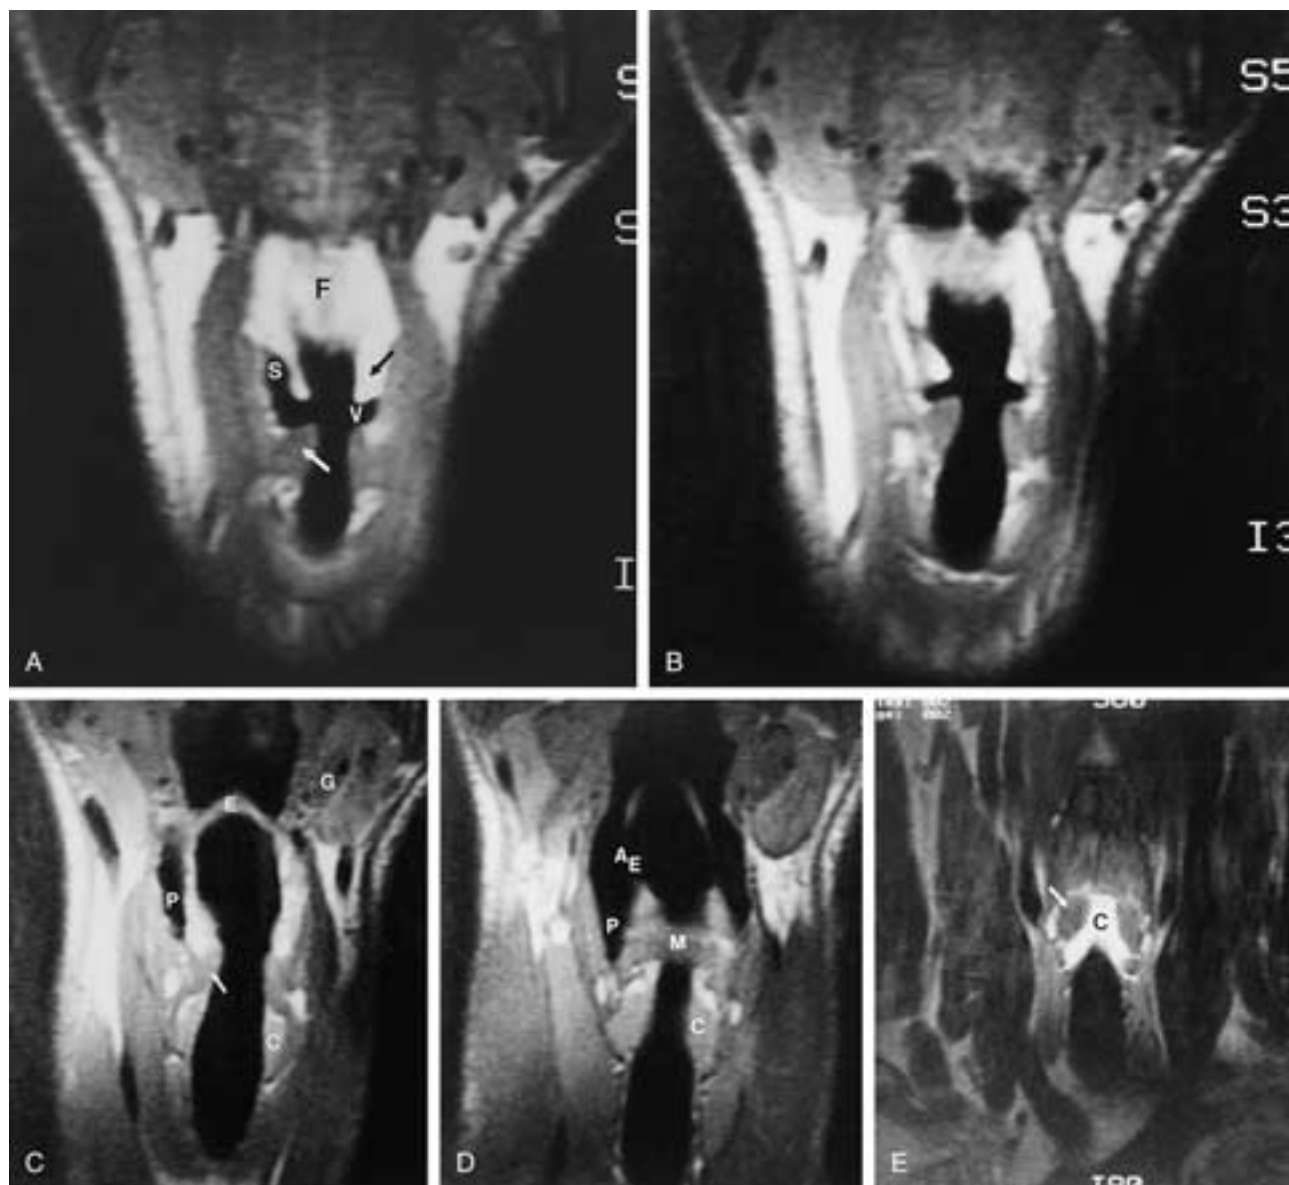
Coronal MR image, 1.5 Tesla, T1-weighted image seen from front to back. A, Anterior scan shows the muscle intensity (*white arrow*) of the TAM at the level of the cord. The paraglottic space at the level of the false cord shows bright fat intensity (*black arrow*). *V*, Ventricle; *S*, saccule of the ventricle; *F*, preepiglottic fat. B, Slightly more posterior scan. C, More posterior to B. *Arrow*, Posterior TAM; *P*, pyriform sinus; *E*, epiglottis; *C*, cricoid; *G*, submandibular gland. D, Posterior to C. *C*, Cricoid lamina; *M*, interarytenoid muscle; *AE*, AE fold; *P*, pyriform sinus. E, Posterior larynx shows the posterior cricoid (*C*). The muscle intensity to either side (*arrow*) represents the posterior cricoarytenoid muscle. (From Curtin HD. Imaging of the larynx: current concepts. Radiology 1989;713:1–11.)
